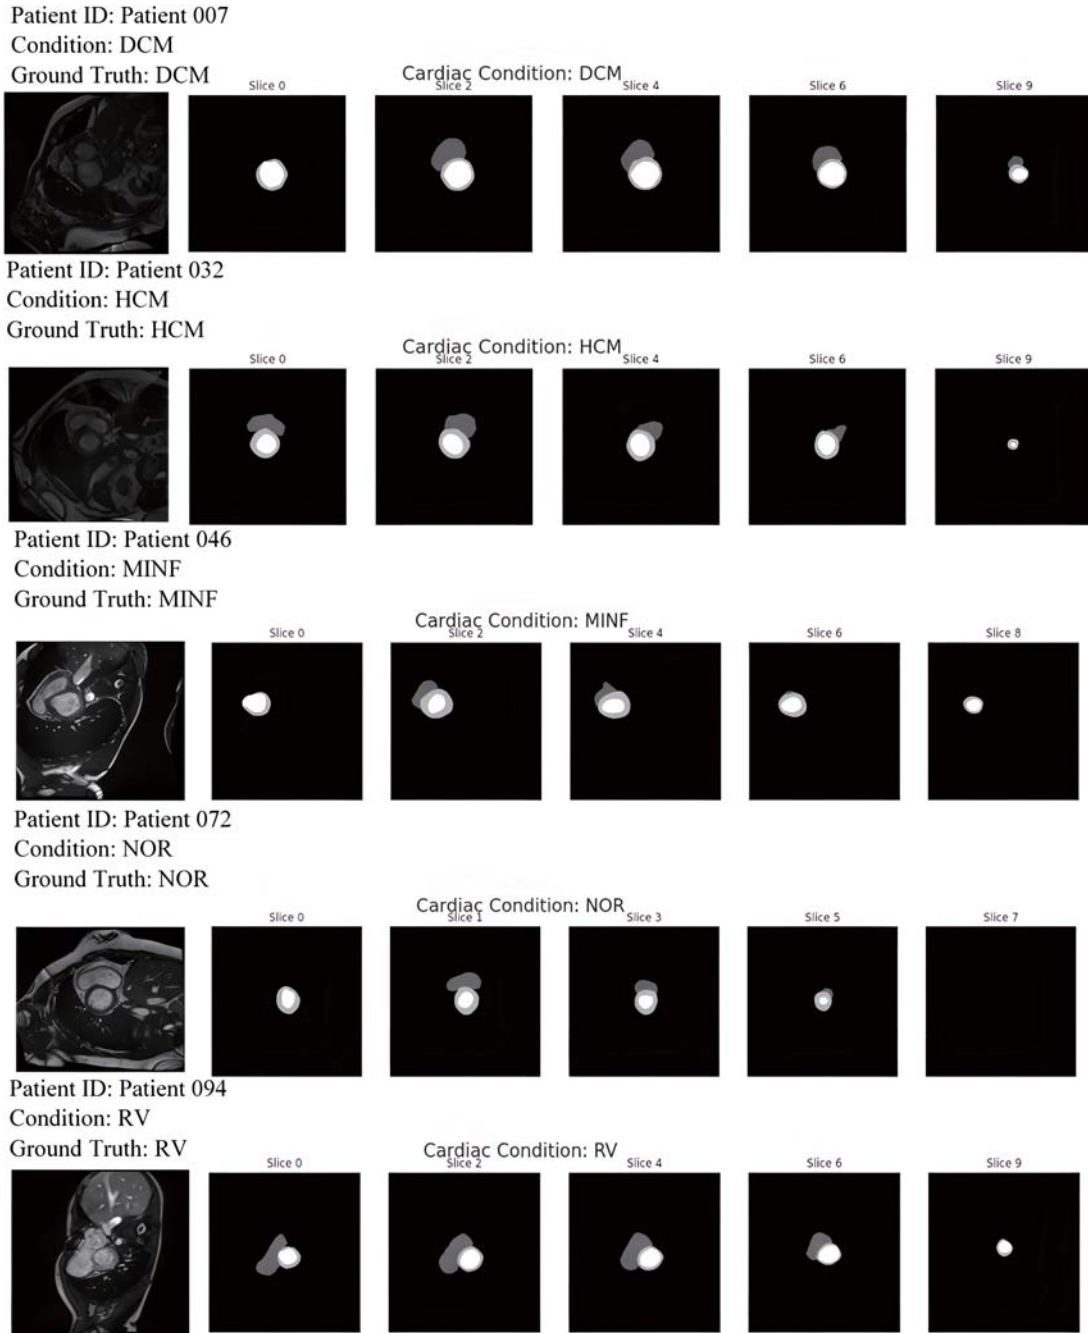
Representative cardiac MRI slices.
